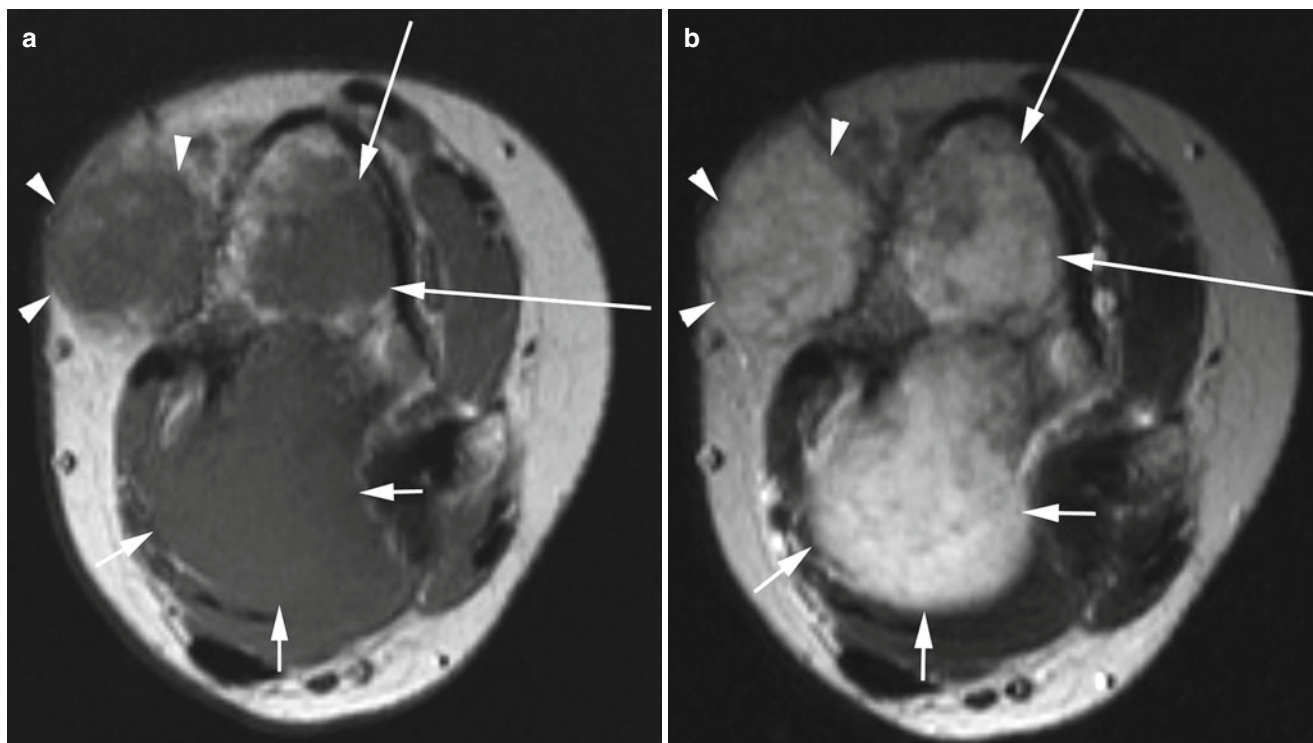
(a–c) Multiple hemangiomas in a patient with Mafucci syndrome, located in the subcutaneous tissue (*arrowheads*), muscle (*short arrows*), and bone (*long arrows*). In the T1-weighted image (a) intramuscular hemangioma (*short arrows*) is isointense to muscle tissue and hardly discernible from normal muscle. In the T2-weighted image
